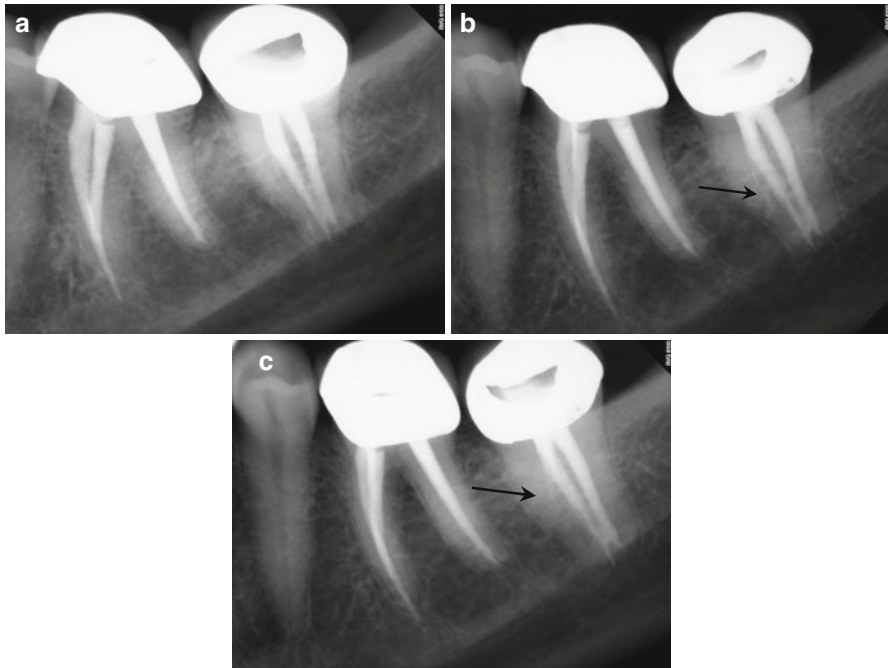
(a–c) Preoperative radiographs from several different angulations fail to disclose a definitive diagnosis. However, closer examination of the magnified image suggests a thin radiopaque line from the mesial canal in two of the images (*black arrows*). The obturation is also off-center, again suggestive of additional canal spaces within the root. (d) The axial, coronal, and sagittal sections of the CBCT scan reveal a high-density dot or line, highly suggestive of sealer extruded into the uninstrumented ML canal space (*white arrows*). (e) The colorized 3-D axial section highlights the high-density object adjacent to the MB canal; the direction is on a line from the ML canal to the ML line angle of the root surface (*red arrow*). (f) The colorized 3-D coronal section reveals the bifurcation of the main canal, with sealer streaming into the lingual aspect of the bifurcation (*yellow arrow*). (g) A magnified view of the colorized coronal section with part of the sagittal aspect of the root removed. The detail of the bifurcation is displayed, and accurate measurements regarding depth can be obtained. It was ascertained from the scan that the depth from the floor of the chamber to the bifurcation entrance was 4 mm, on an angle toward the ML line angle of the mesial root. (h, i) The root canal filling (RCF) was harvested from the canal spaces, and the ML canal was located and negotiated (*black arrow*). A periapical radiograph was exposed to verify the complete removal of the RCF material. The canals were treated with $\text{Ca}(\text{OH})_2$ for 3 weeks; the patients' symptoms subsided in 1 week and were absent at the completion appointment. (j, k) Right-angle and off-angle radiographs of the completed case, demonstrating the presence of three canals with multiple anastomoses between them
